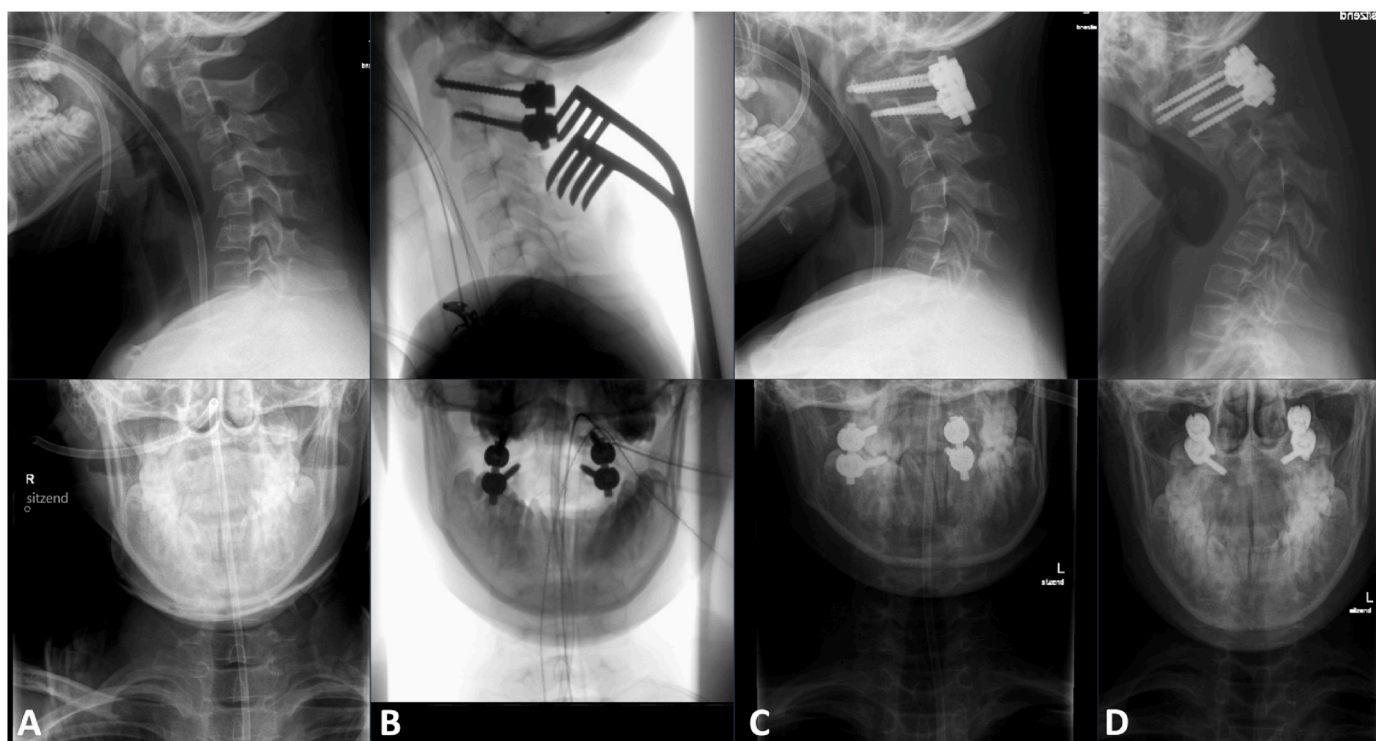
A Sitting lateral and ap radiographs of the cervical spine with persistent atlantoaxial instability after repeated halo fixation B intraoperative fluoroscopy after C1/2 stabilization C radiographs one month postoperative and D four months postoperative show progressive cervical kyphosis.
